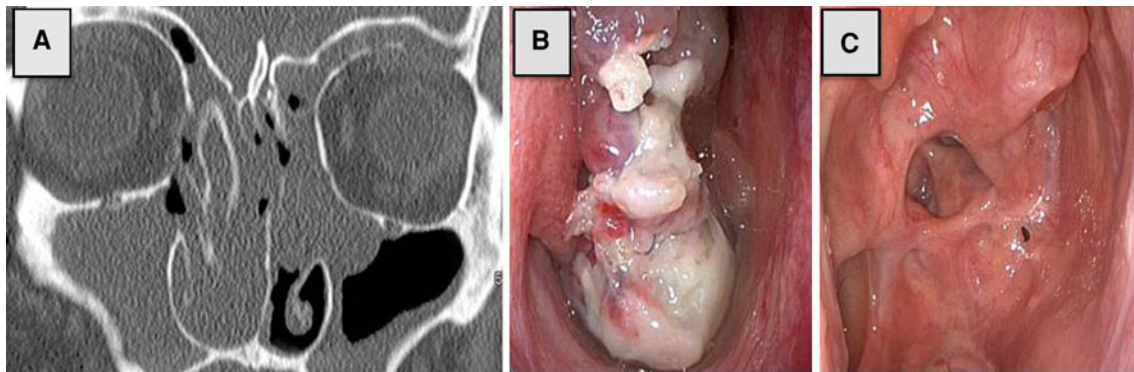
Case 2: The CT-scan shows a tumour with a bony shell in the right ethmoid cells and the main nasal cavity with slight impression of the medial orbital wall and a polyposis on both sides (a).
